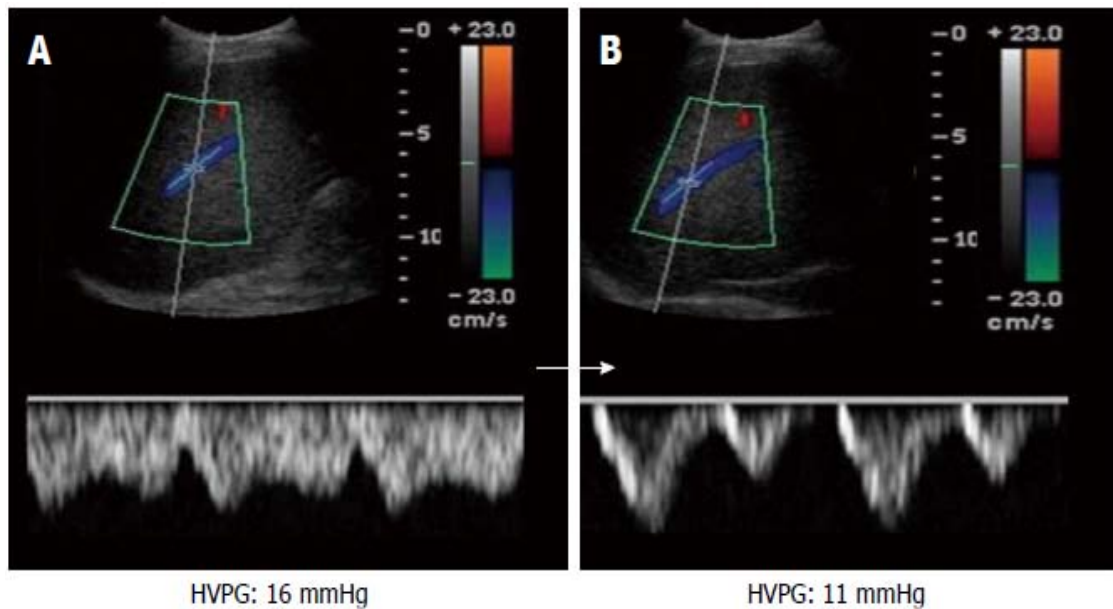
Doppler US showing change in the hepatic vein waveform and damping index (A) before and (B) 3 months after propranolol treatment in a patient with liver cirrhosis
